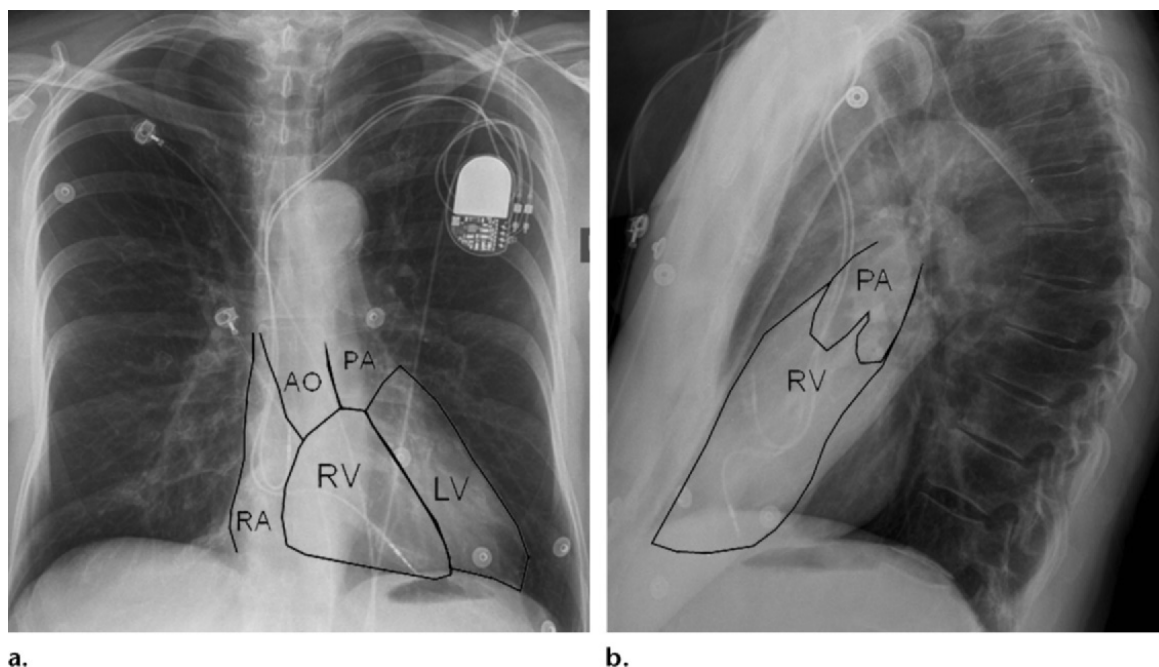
Normal cardiac anatomy. Frontal (a) and lateral (b) chest radiographs show the aorta (AO in a), left ventricle (LV in a), main pulmonary artery (PA), right atrium (RA in a), and right ventricle (RV). “(With permission from Aguilera AL: Radiographics. 31:1669-1682,2011.)
